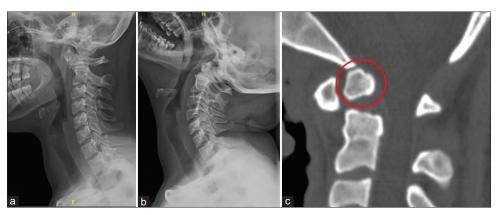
Radiographs of cervical spine in neutral (a) and extension (b), demonstrating the reducible atlantoaxial dislocation. Midsagittal computed tomography scan (c) of the craniovertebral junction showing an os odontoideum (red circle)
